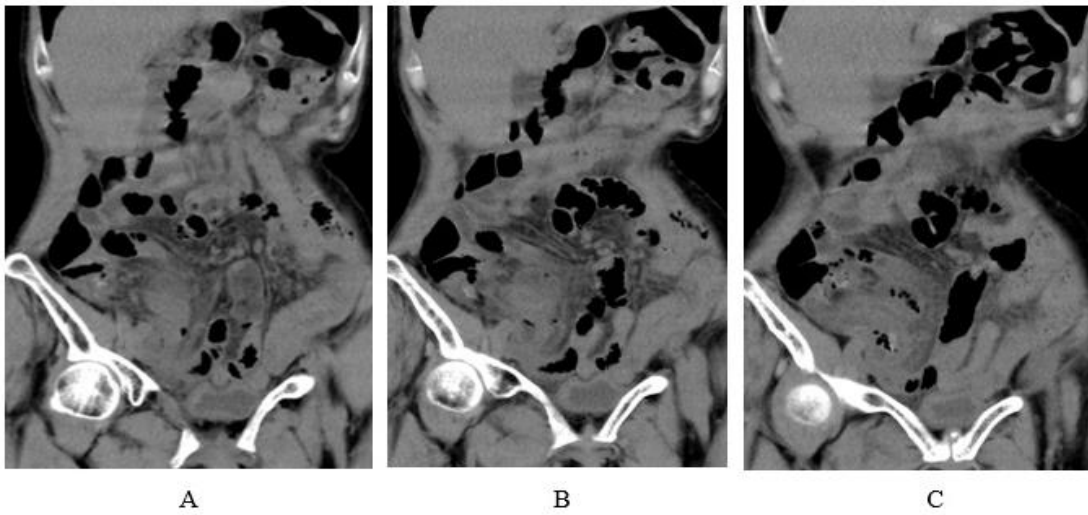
A tubule with mural thickening looking like appendicitis is depicted on coronal CT (A-C)
